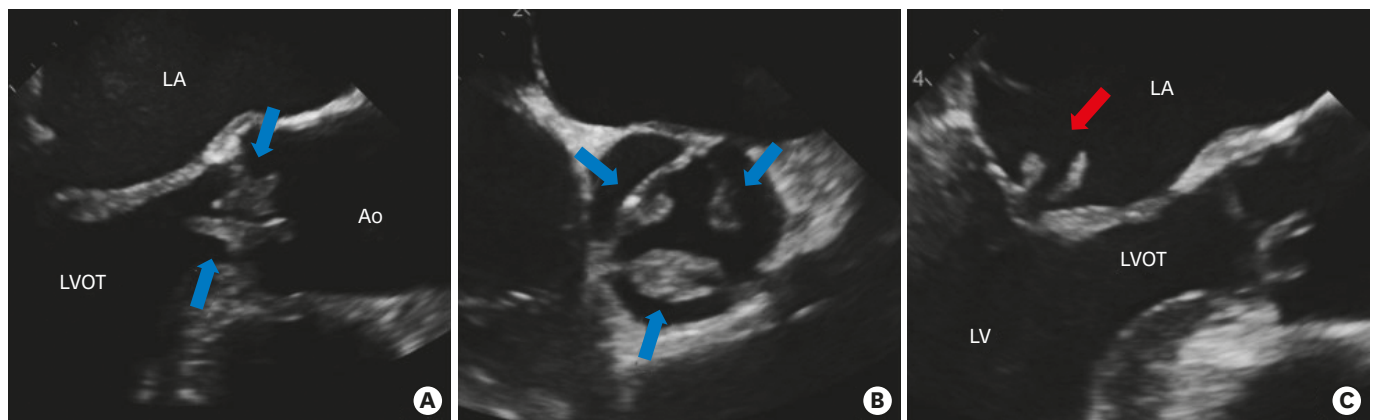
Transesophageal echocardiogram. (A) Midesophageal 170 degree view: AV. Vegetations were observed. (B) Midesophageal 70 degree view: AV. Vegetations were observed at NCC, RCC and LCC. (C) Midesophageal 150 degree view: MV. Vegetations were observed at MV posterior and anterior leaf. Red arrow: echogenic mass at MV; Blue arrow: echogenic mass at AV. LV: left ventricle, LA: left atrium, LVOT: left ventricular outflow tract, Ao: aorta, MV: mitral valve, AV: aortic valve, NCC: non-coronary cusp, RCC: right coronary cusp, LCC: left coronary cusp.
